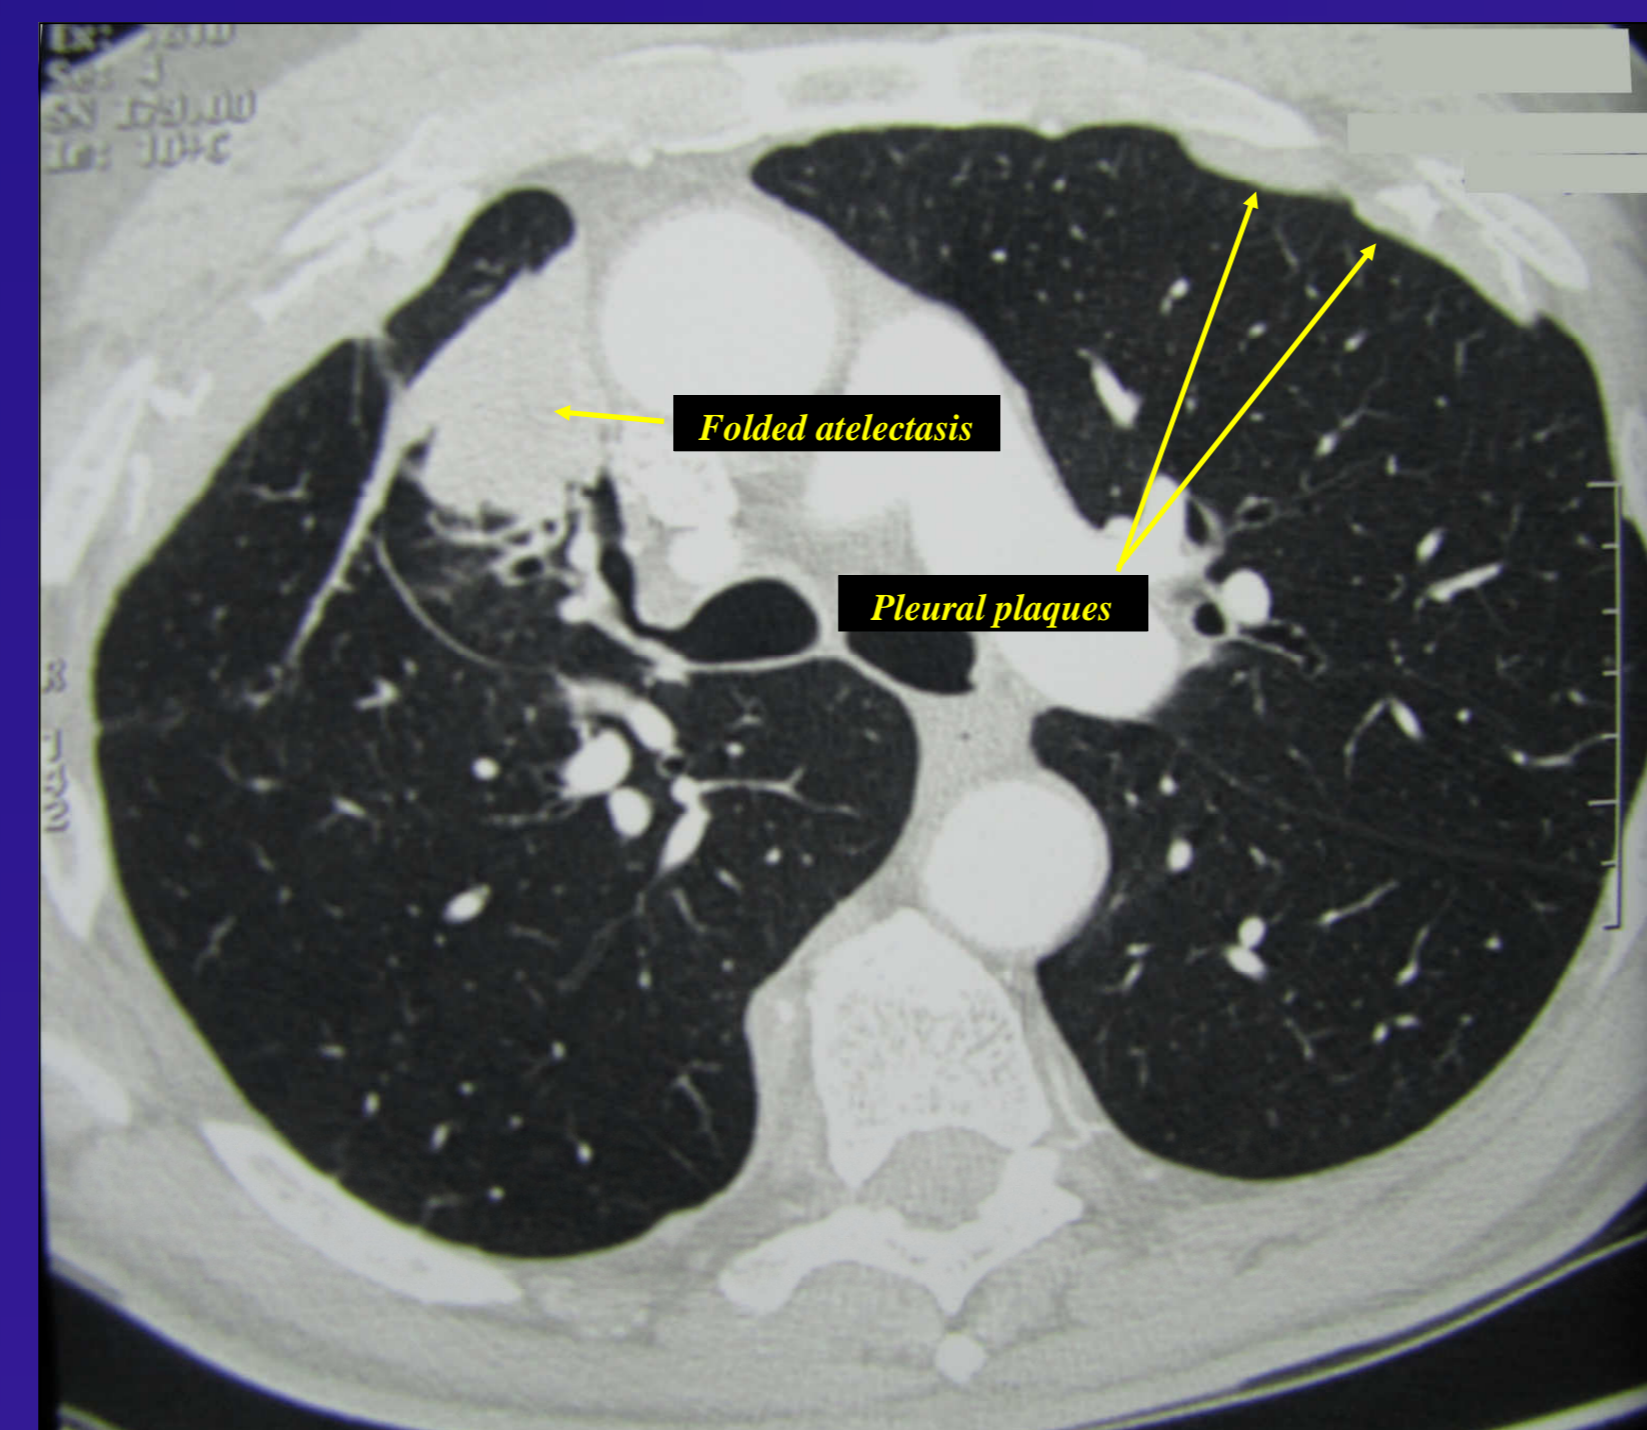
CT chest scan indicating pleural plaques and folded atelectasis.
